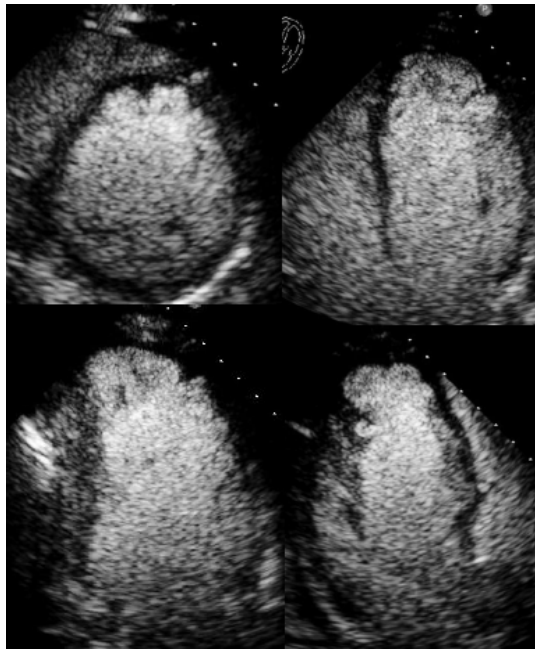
Contrast-enhanced echocardiographic views (same as in Figure 2). Contrast echocardiography is used to prove the continuity of blood from left ventricular cavity into intertrabecular recesses and to enhance the endocardial border delineation.
